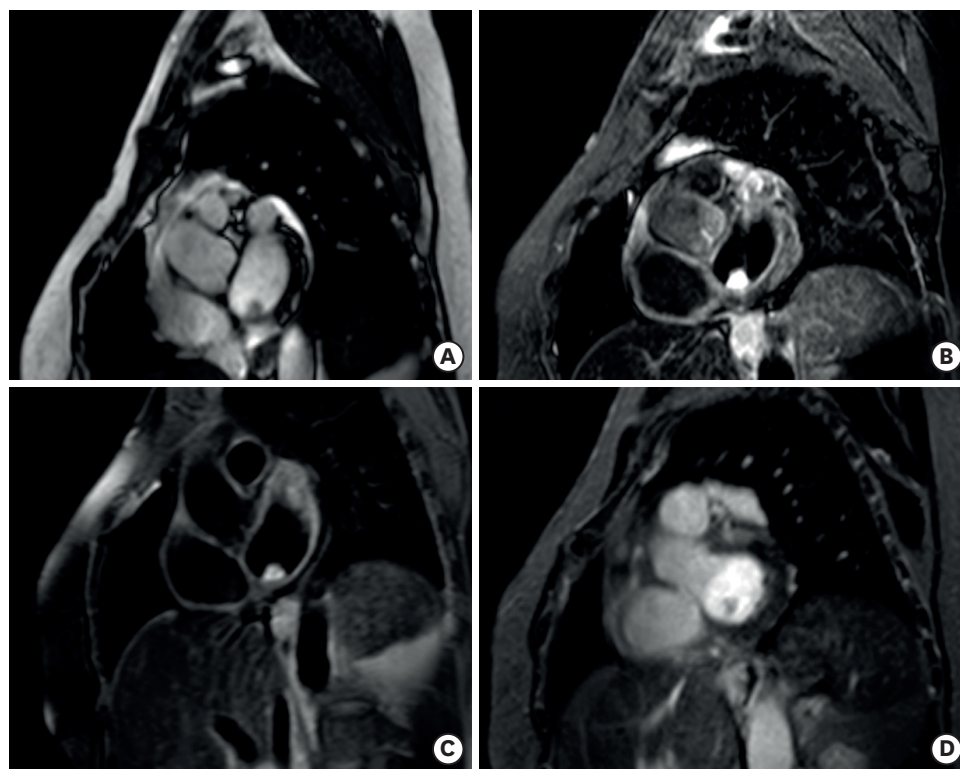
Cardiac MRI. (A) Cine image SSFP sequence of the left atrial mass. (B) High-intensity signal on the fluid-sensitive sequence (T2 STIR). (C) High-intensity signal on the fat-suppressed image. (D) Left atrial mass with heterogeneous mild late contrast enhancement. SSFP: steady-state free precession, T2 STIR: short inversion time inversion recovery.
